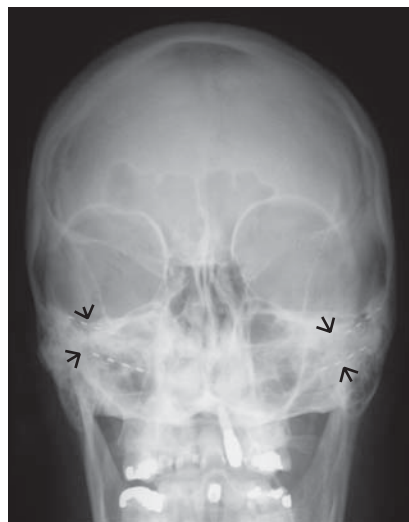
Final placement of 2 cylindrical leads (arrows), to the right and left-side under standard PA x-ray view.
